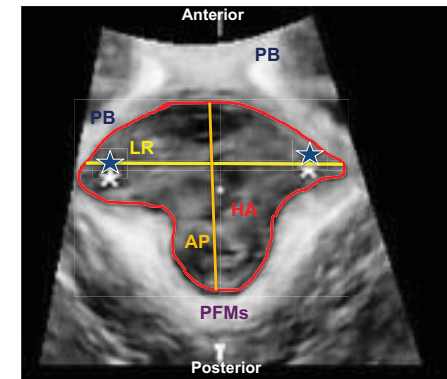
Representative ultrasound image of complete bilateral trauma to the pelvic floor muscles with biometry indicated. LR = left-right diameter; AP = anteroposterior diameter; HA = hiatal area; PFMs = pelvic floor muscles; PB = pubic bone. ★ indicate tearing of muscle from pelvic bone [3].
